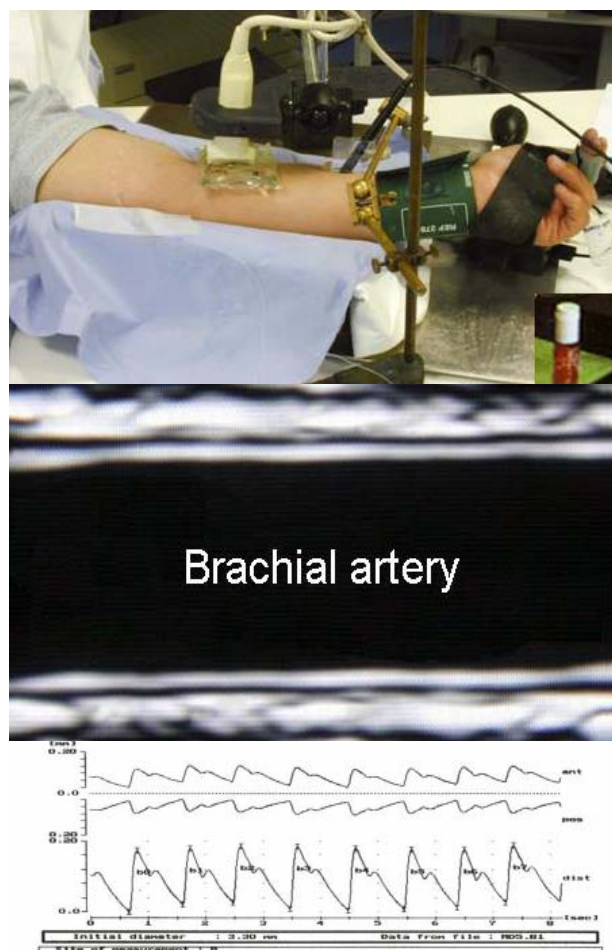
Assessment of endothelial dysfunction by flow mediated vasodilatation (FMD). Upper panel: ultrasound probe, positioned using a probe-holder, imaging the brachial artery; shear stress is induced by releasing a sphygmomanometric cuff after a 5-minutes over-inflation (at least 50 mmHg above systolic blood pressure in order to occlude the arterial inflow) at the forearm level. Mid panel: high-quality ultrasound image of the brachial artery. Lower panel: anterior and posterior wall tracking of the brachial artery, with the beat-to-beat variations of the arterial diameter; diameter is measured at baseline and after reactive hyperemia, and flow-mediated vasodilatation (FMD) is typically expressed as the change in post-shear stress diameter as a percentage of the baseline diameter.
